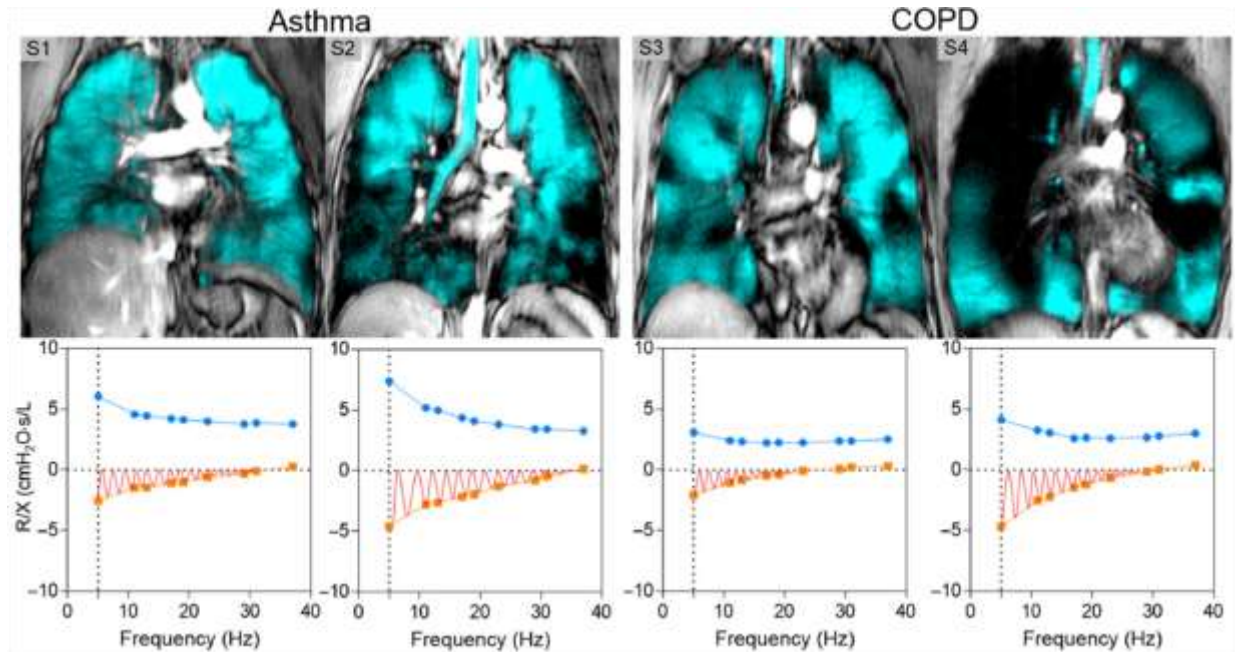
Qualitative analysis of Heterogeneity. S1 & S2 hyperpolarized He MRI imaging of two Asthmatic subjects with less and higher heterogeneity reflected in the ventilation in turquoise with the thoracic cavity in gray scale. Respectively oscillometry images of the patients showing resistance in blue and reactance in orange with respect to frequencies. The hatched area in orange is A_x which is not studied in this thesis. S3 & S4 shows respective COPD patients MRI images and oscillometry plots. (reproduced with permission from [27])
